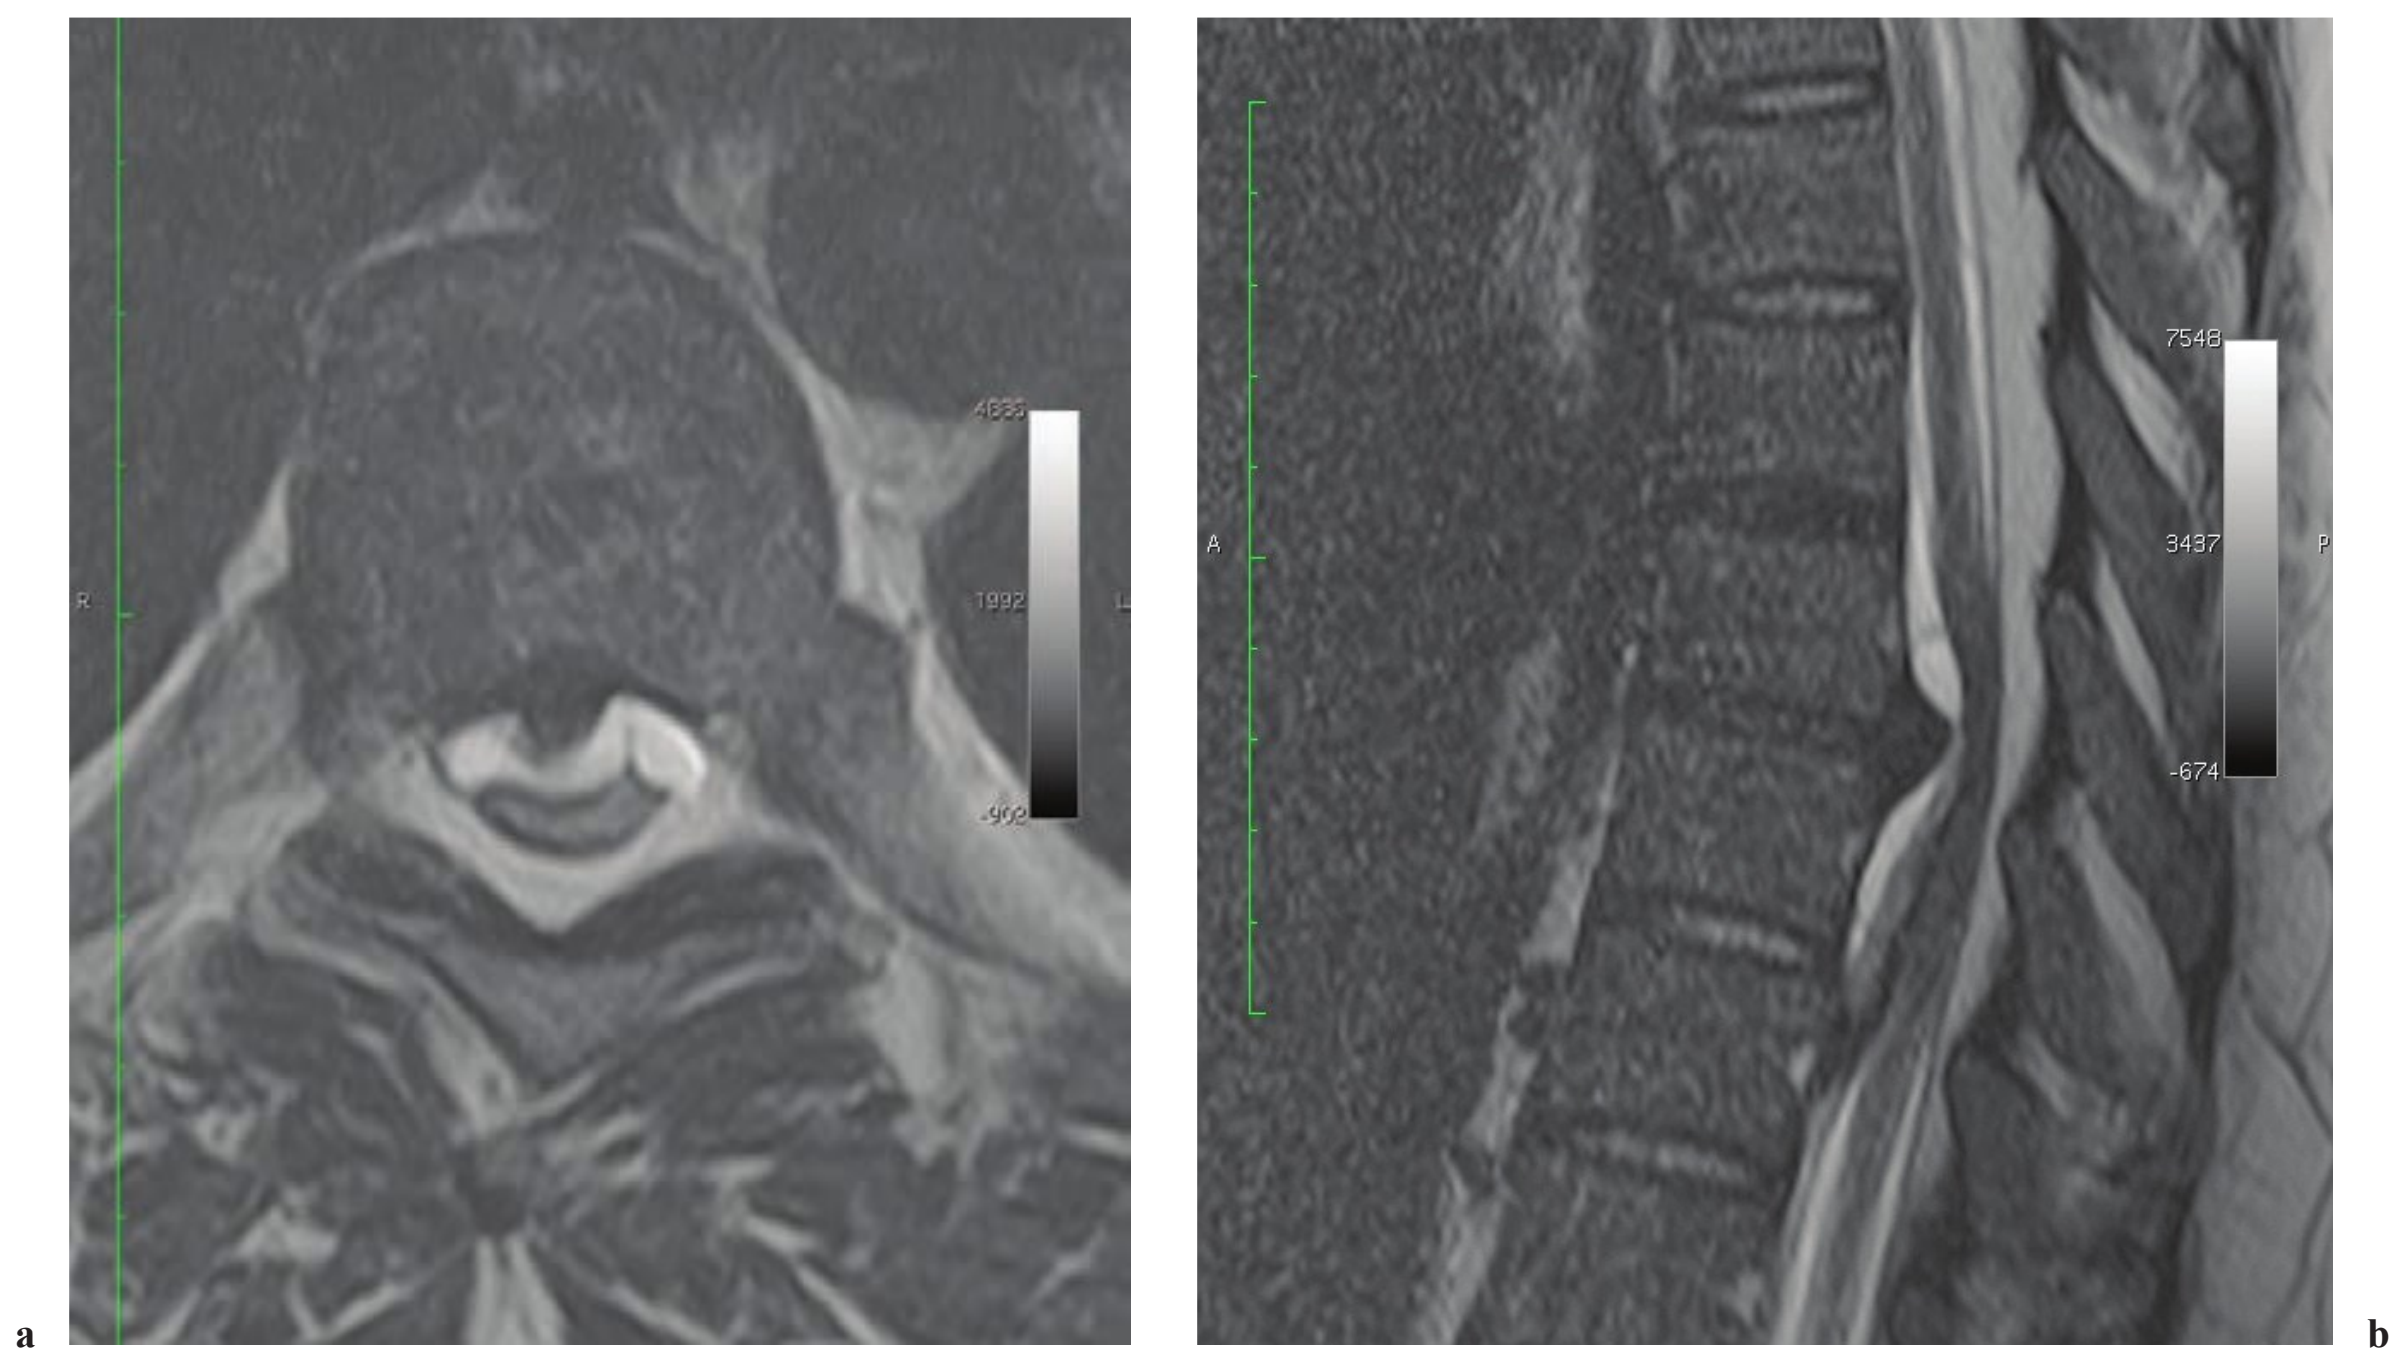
Spinal epidural hematoma. (a) Axial and (b) sagittal MRI in a patient with focal spontaneous hematoma around the central herniated disk located ventral to the cord.
